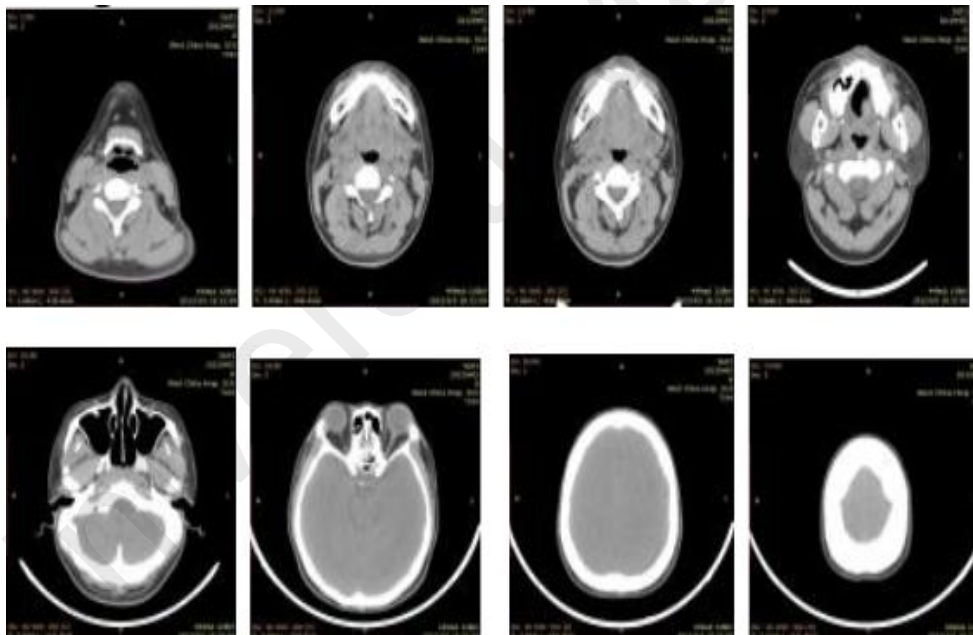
13 The CT Head Image Data
